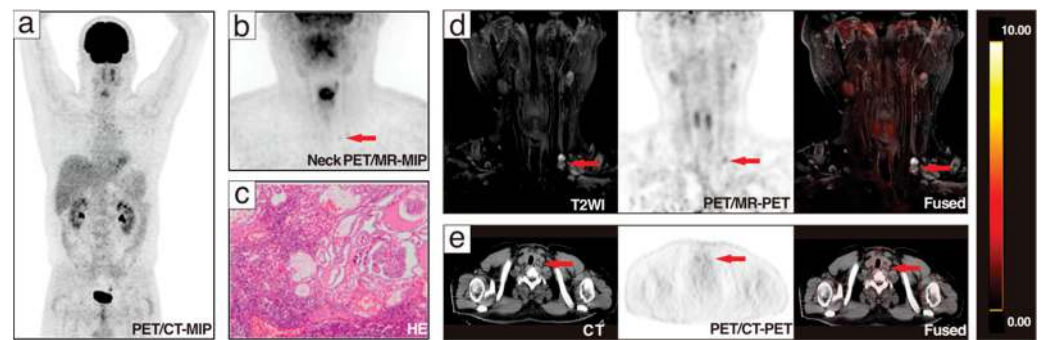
A 36-year-old patient with Tg 39.1 $\mu\text{g/L}$ and negative ^{131}I -WBS after comprehensive treatment was admitted to ^{18}F -FDG PET/CT and underwent additional neck PET/MR. PET/MR clearly presented the morphological and metabolic changes of lymph nodes in the VB region ((b,d), red arrows). PET/CT showed no significant changes in the corresponding lesions ((a,e), red arrows). After reoperation, 1 lymph node in the left VB, 8 lymph nodes in the left level IIA, 7 lymph nodes in the left level III, and 10 lymph nodes in the left level IV were taken for pathomorphological examination, and only the lymph node in the VB was pathologically diagnosed to be a metastatic lymph node (c).
